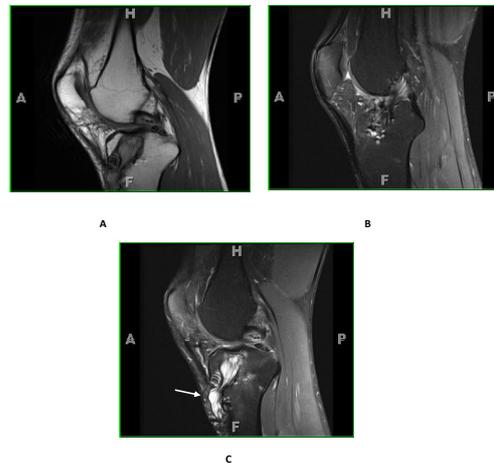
(a) Sagittal PD (b) Sagittal PD with fat sat. (c) Sagittal STIR MR images show partial tear of ACL graft, ganglion cyst (white arrow)
